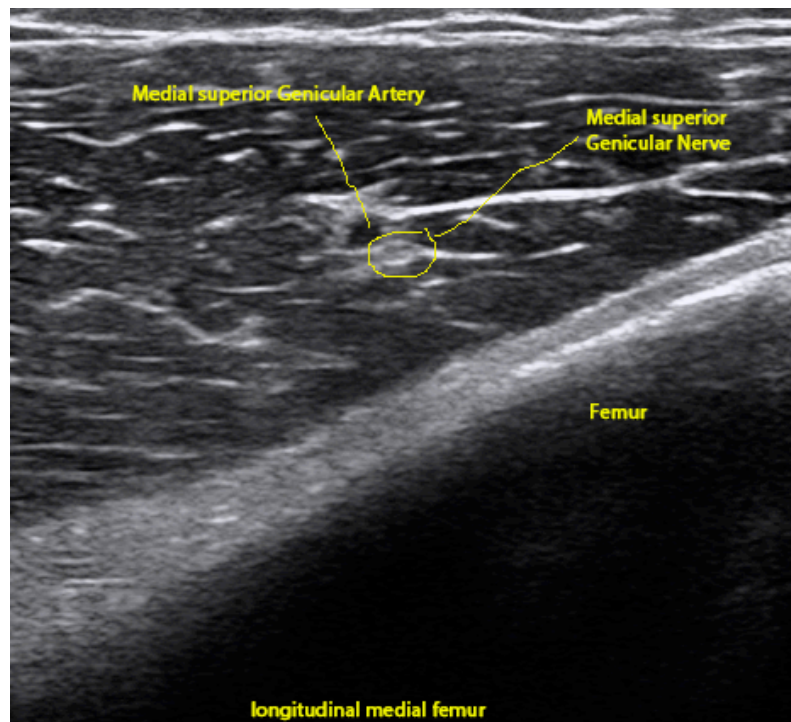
Ultrasound guided superior medial genicular nerve block. The superior medial genicular nerve close to the superior medial genicular artery. Note the relationship of the artery seen on color Doppler imaging and the femoral cortical surface at the transition point between the shaft and the medial condyle.
